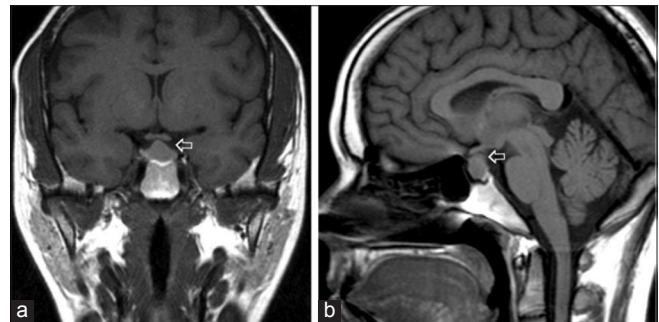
Prolactinoma in a 27-year-old woman who was 32 weeks pregnant and presented with headaches, visual disturbances, and a prolactin level of 290 ng/mL. Unenhanced coronal (a) and sagittal (b) T1-weighted magnetic resonance imaging show a large sellar and suprasellar tumor that causes mild compression of the optic chiasm (arrow)
